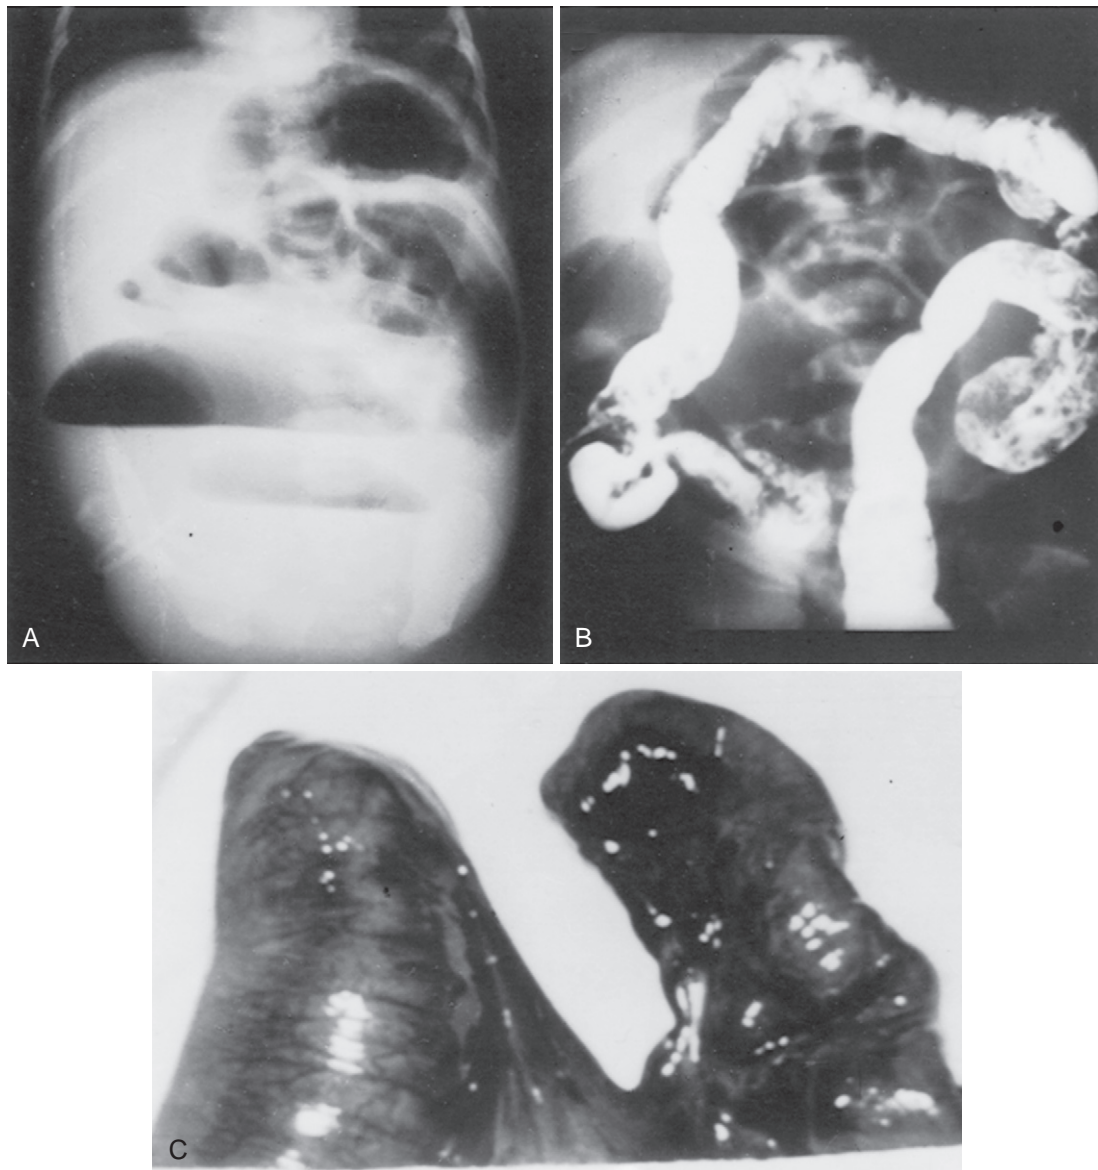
Ileal atresia. A, Upright radiograph of abdomen showing distended loops of intestine with air fluid levels. B, Contrast enema showing normal-caliber colon filled with debris. C, At laparotomy, ileal atresia with a V-shaped defect in the mesentery (type IIIa) and evidence of an intrauterine intussusception were found. (From Grosfeld JL: Alimentary tract obstruction in the newborn. *Curr Probl Pediatr* 1975;5:3).
